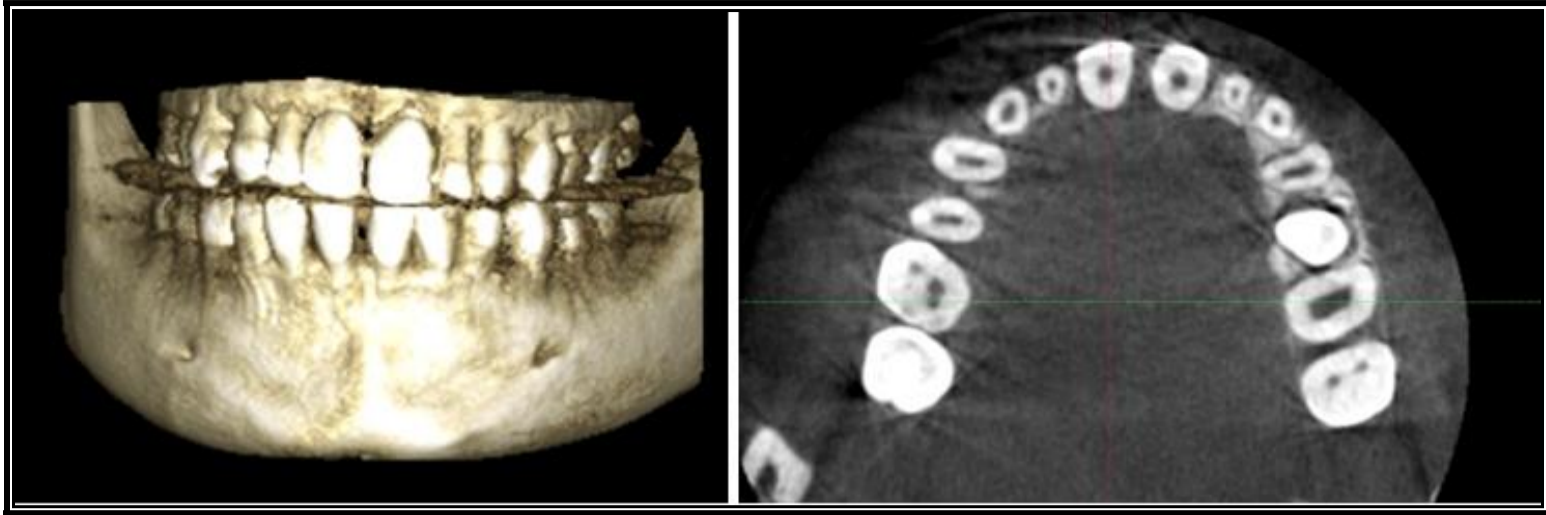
CBCT examination of the upper arch
